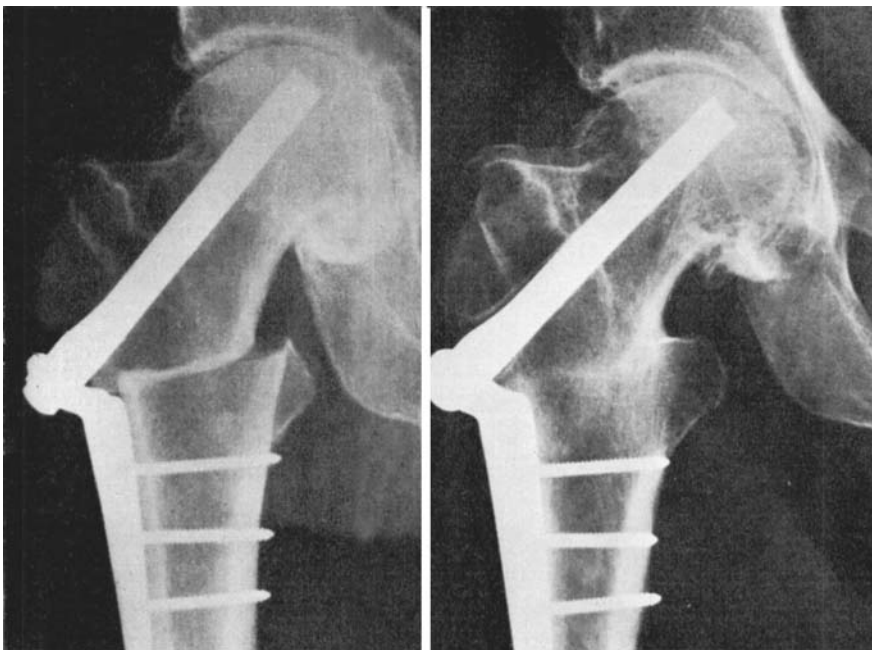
Radiographic appearances immediately after intertrochanteric displacement osteotomy and 2 years later when the osteotomy shows sound union.
